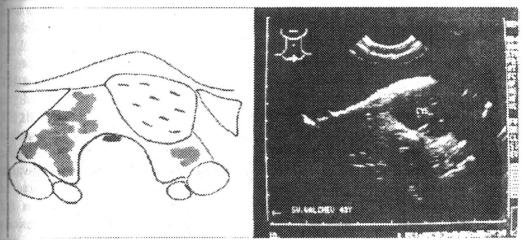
Ultrasonographic image in a patient with ST
